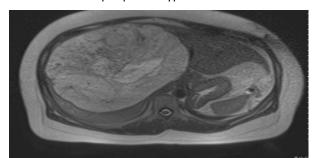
MRI one month later with growth of liver mass to 18 cm with central cystic changes.
